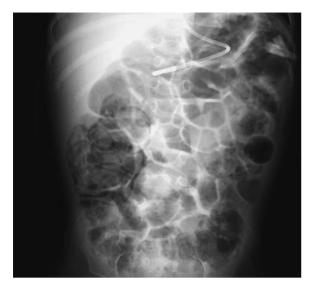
Abdominal radiograph showing thickening of the cecal wall and intramural gas consistent with typhlitis in this immunocompromised patient
